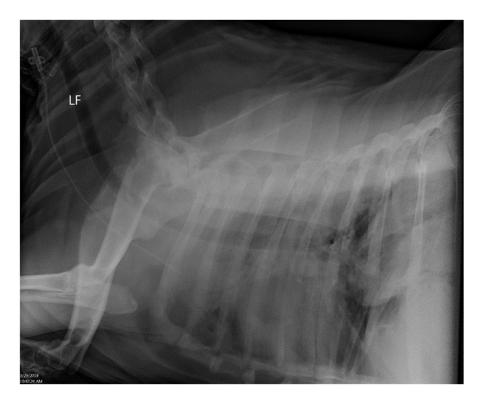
Thoracic radiograph showing a multilobar interstitial to alveolar pattern, most suggestive of bronchopneumonia with secondary pleural effusion.
